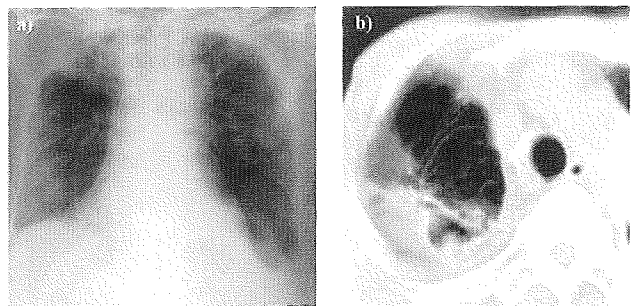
(a) Chest radiograph on admission showed pleural thickening in the right upper lung field (Case 1). (b) Chest CT showed a mycetoma of 20 × 18 mm in size within the cavity, the wall of which was thickened and had invaded the surrounding parenchyma (Case 1).
